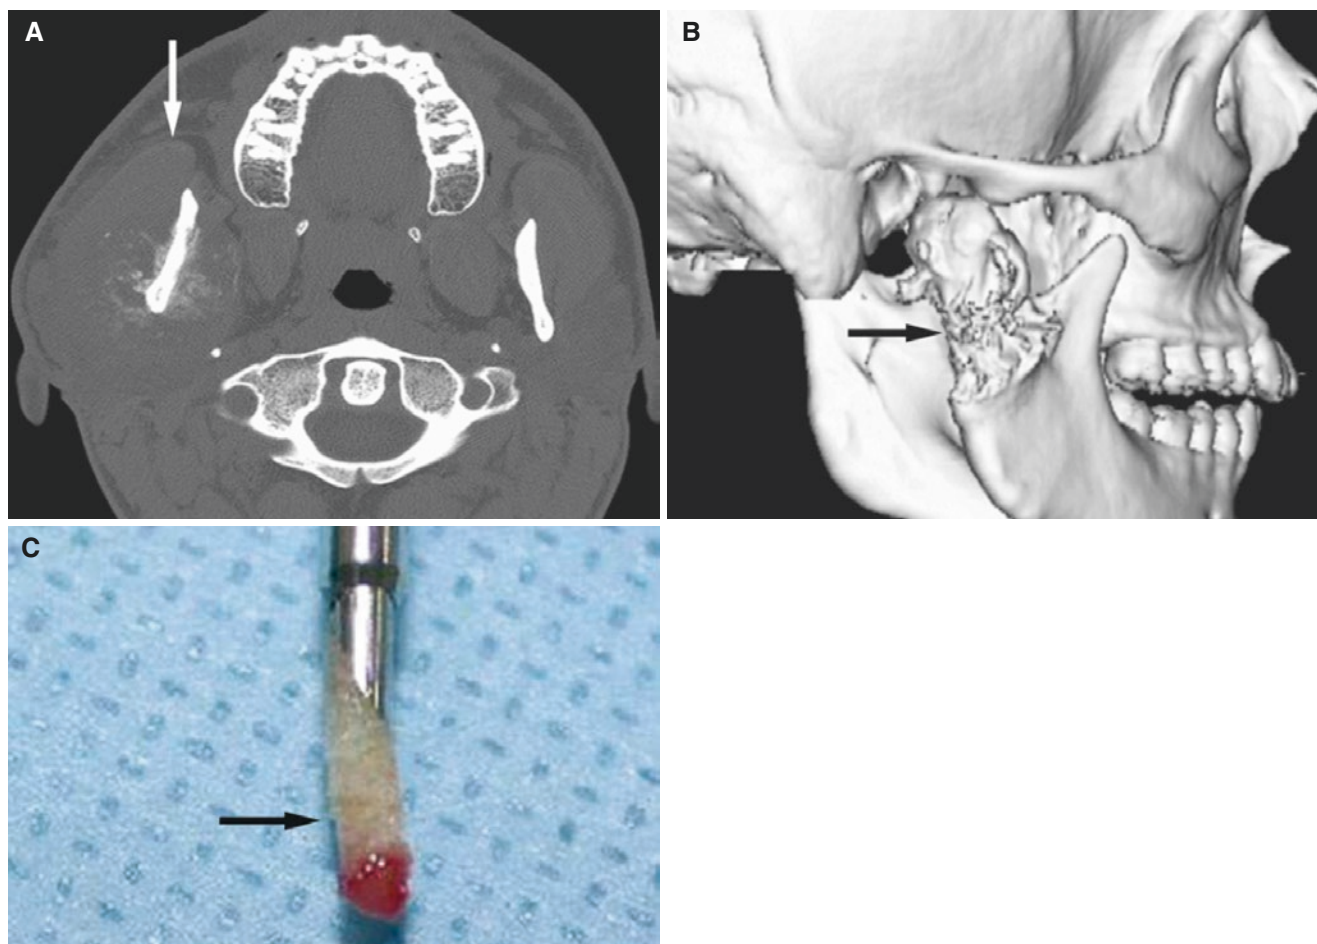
Bone biopsy of mass around mandibular ramus. (A) Axial CT image shows soft-tissue mass with extensive sunburst periosteal bone reaction (*arrow*). (B) 3D CT image depicts relationship between
